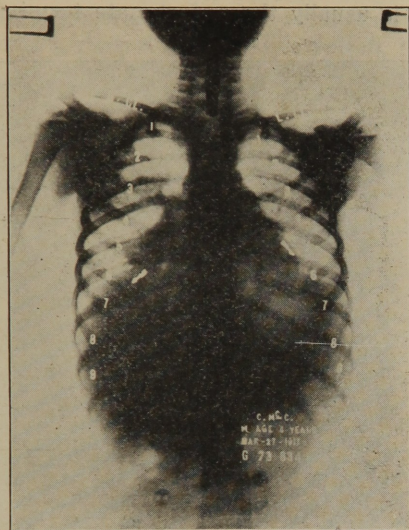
Radiograph of a patient intubated for laryngeal diphtheria. The lumen of the intubation tube became obstructed, which caused retention of secretion and "sponge soaking" of the lungs. The dark triangular area in both lungs is the gradual "sponge soaking" from below upward. The condition was diagnosed bronchopneumonia, but was promptly relieved after the removal of the tube and bronchoscopic evacuation of the retained secretion.
